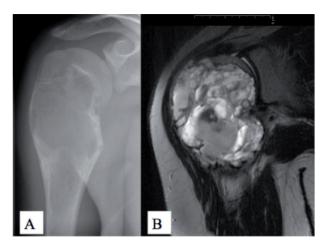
Patient 2. 1A: Radiographic image at presentation. 1B : T2-weighted MRI at the first recurrence (10 months later).
